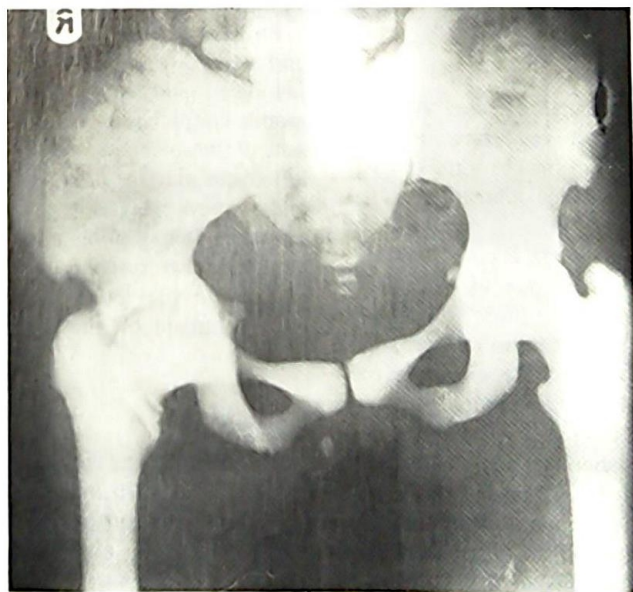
X-ray of patient's pelvis — showing generalized bone sclerosis with obliteration of the medulla in the femur.
